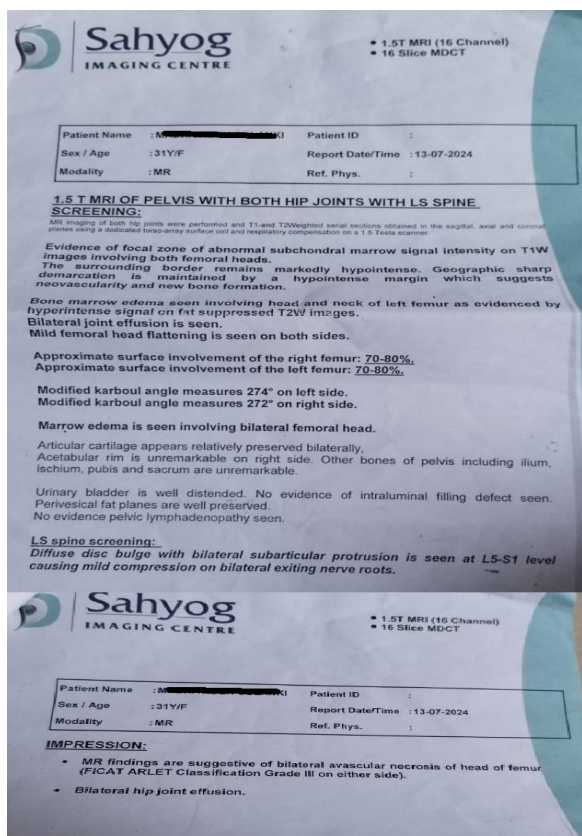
BT- Radiological report (MRI – 13/07/2024)
